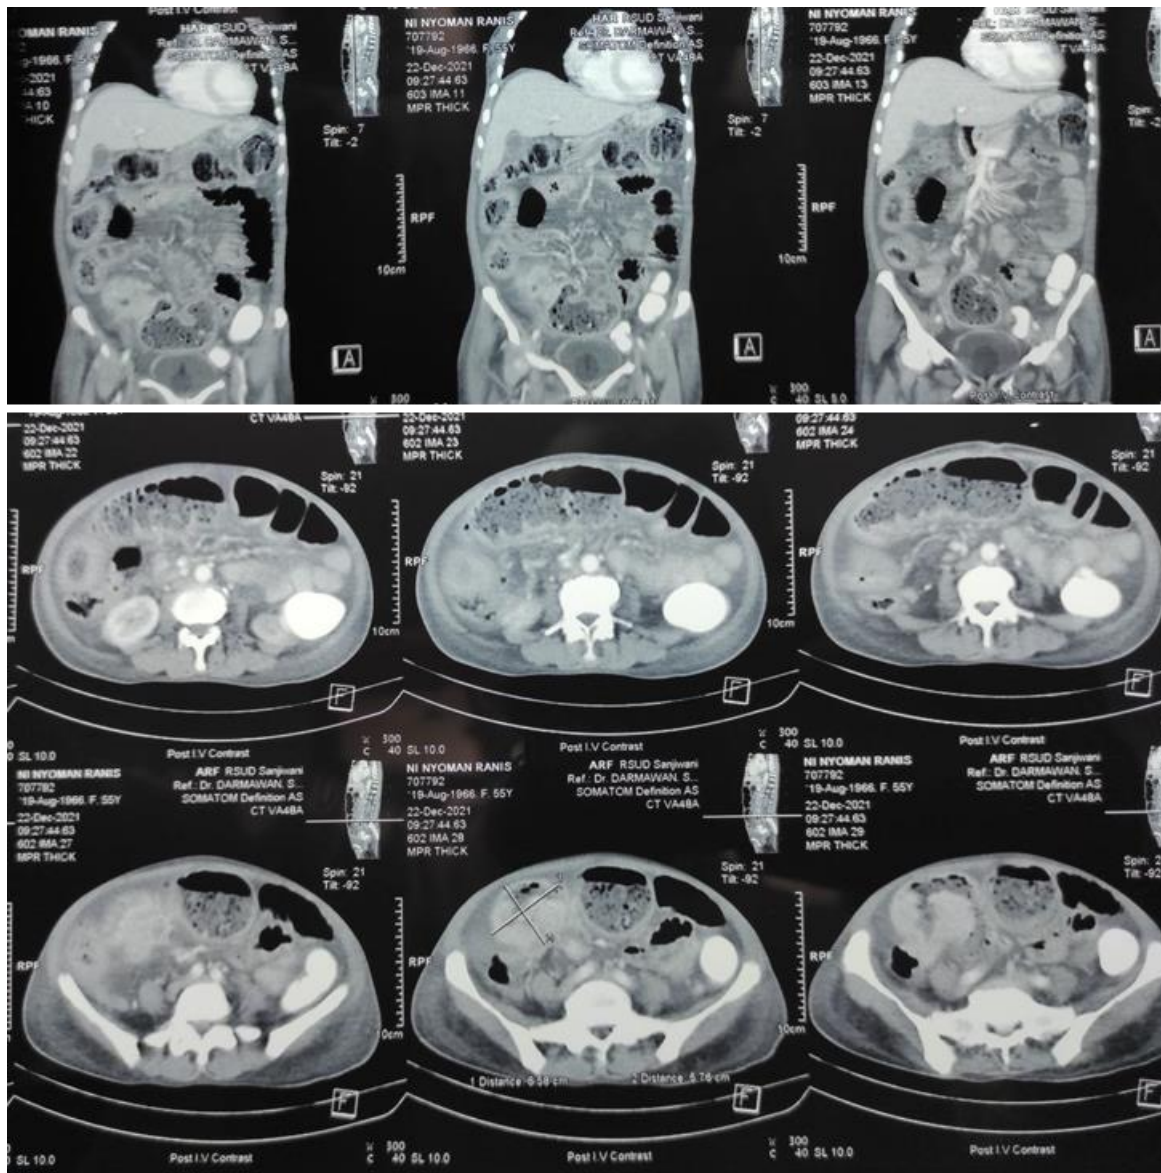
Abdominal CT scan.
